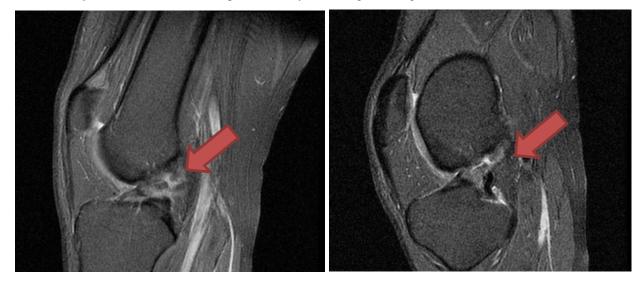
MRI of knee, in sagittal plane proton density sequence. Complete lesion of ACL Gr. III.
